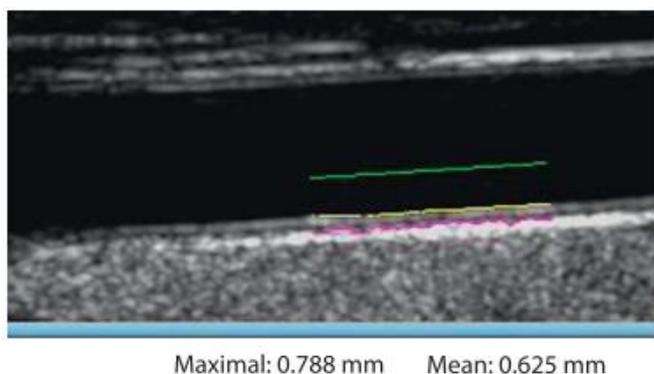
Carotid ultrasound. The yellow line represents the lumen-intima interface and the pink line represents the media-adventitia interface. (40)
